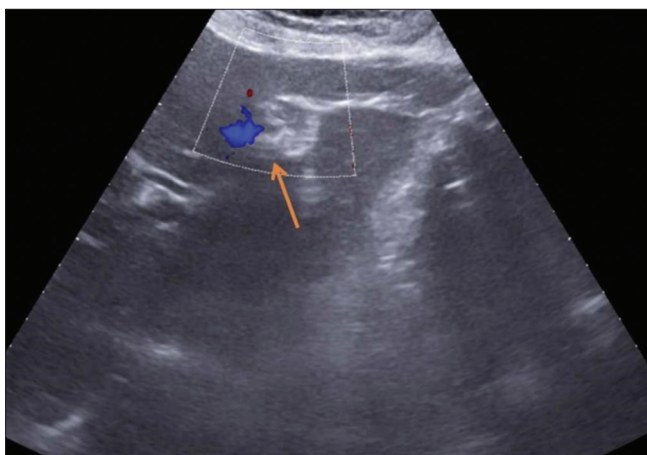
Transverse ultrasound image on follow-up after 2 weeks shows reduced echogenicity of the falciform ligament (orange arrow) with no flow on Doppler study
